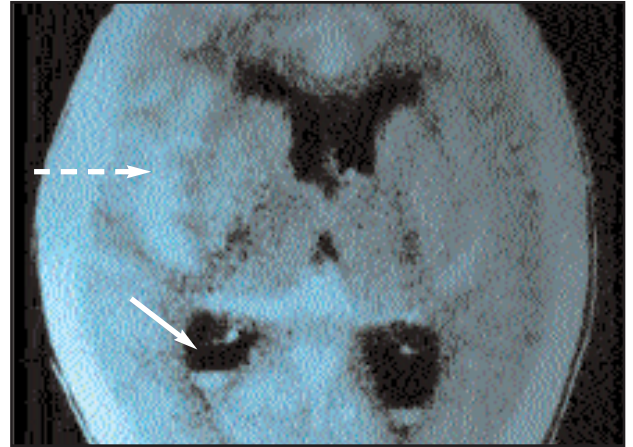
CT head scan without contrast showing acute haemorrhage into the ventricles, subarachnoid haemorrhage (solid arrow) and parenchyma, intracerebral haemorrhage (dashed arrow)
